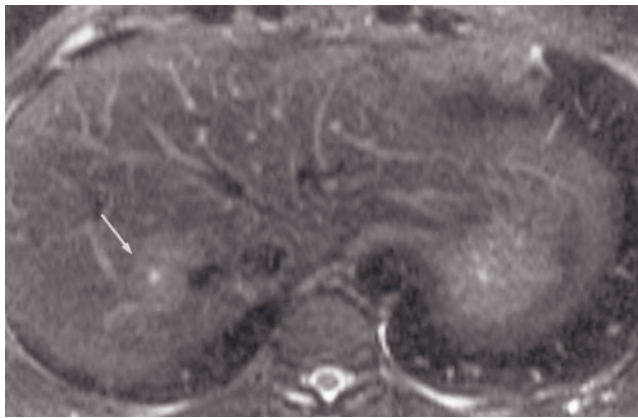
Medium-sized FNH. T2-weighted ETSE (*a*), SGE (*b*), and immediate (*c*) and 5-min (*d*) postgadolinium SGE images.
